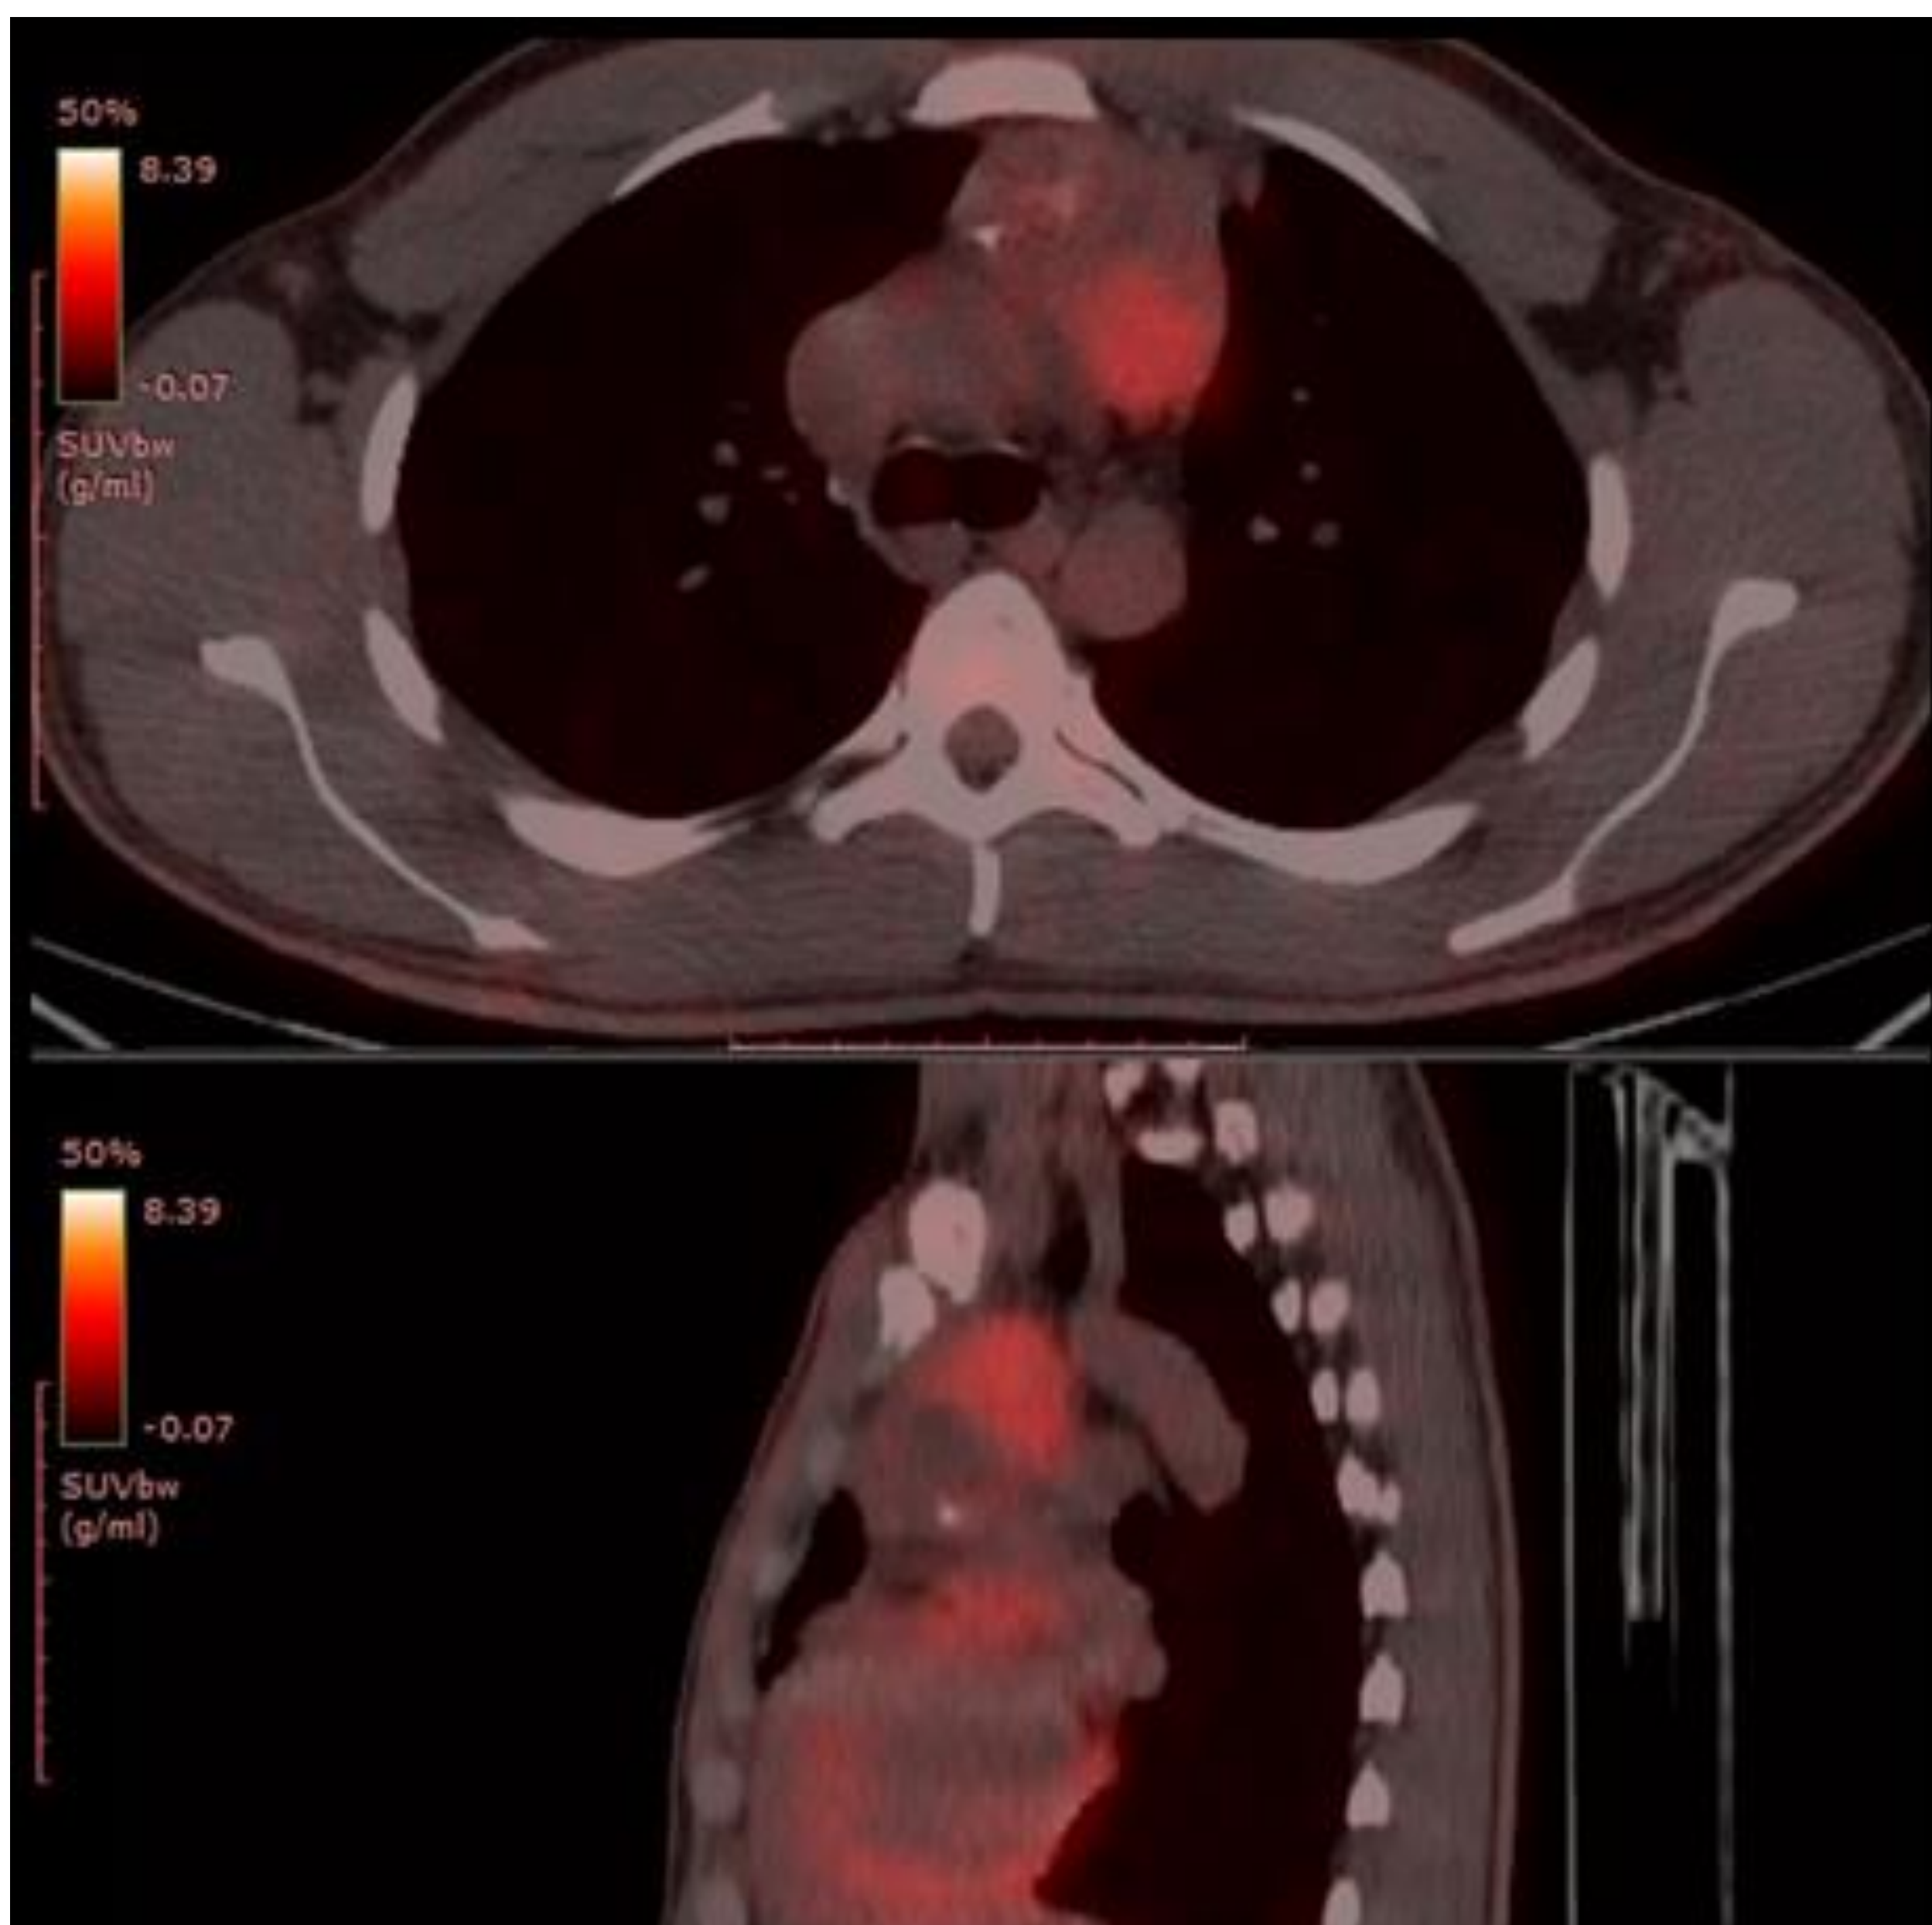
PET/CT of the patient performed due to severe elevation of β -hCG after 6-years follow up demonstrates mediastinal tumor.
